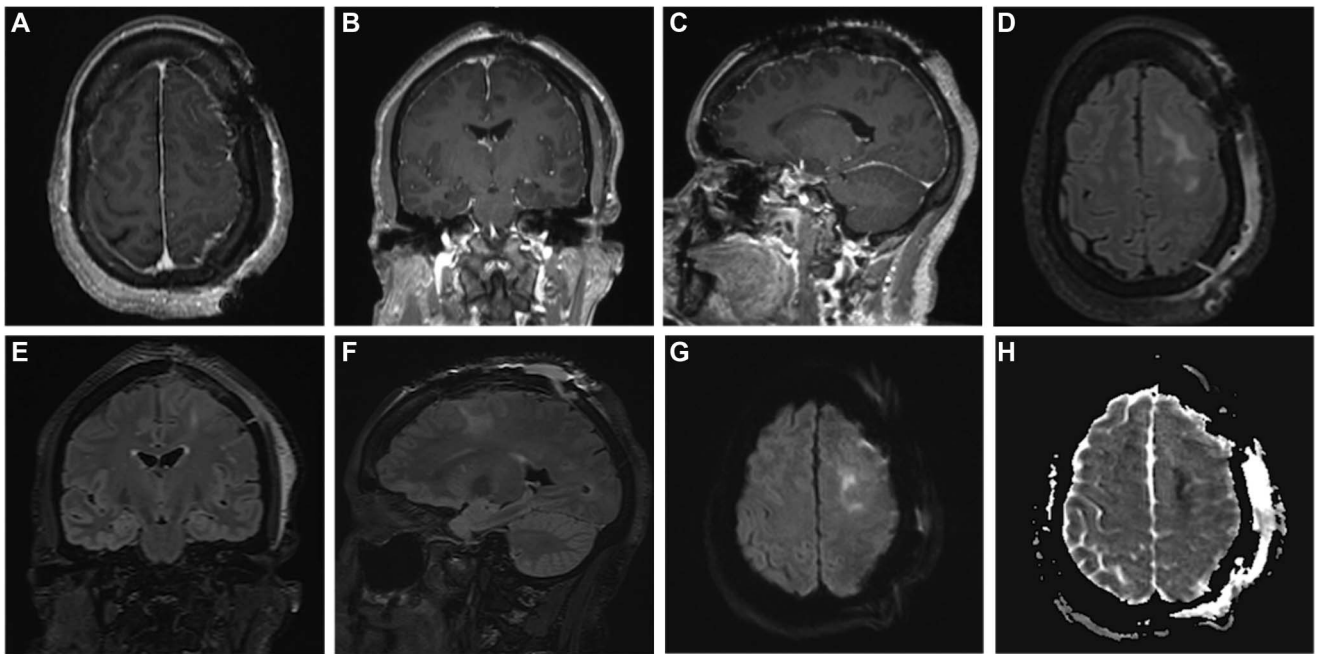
Postoperative A–C, MRI T1-weighted gadolinium contrast-enhanced sequences and D–F, T2-weighted FLAIR sequences demonstrating gross total resection of left parasagittal meningioma. D–F, FLAIR sequences demonstrate stable to improved vasogenic edemas postoperatively. G, H, Postoperative MRI diffusion-weighted sequences show a small region of diffusion restriction over the left supplementary motor area. FLAIR, fluid-attenuated recovery.
